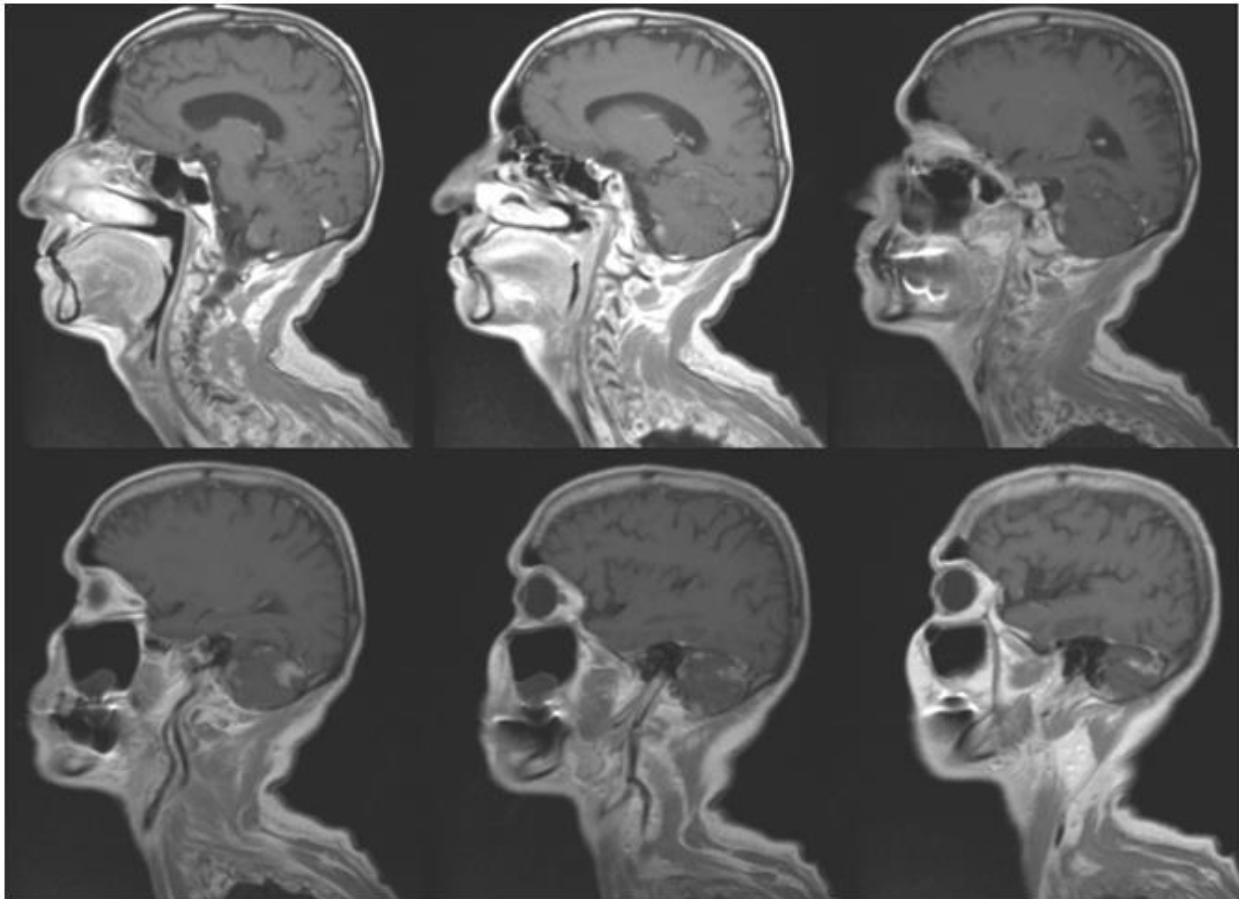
SAG T1 FLAIR+C MR postcontrast images after 4 months of RT and after 3 months of targeted therapy alone
